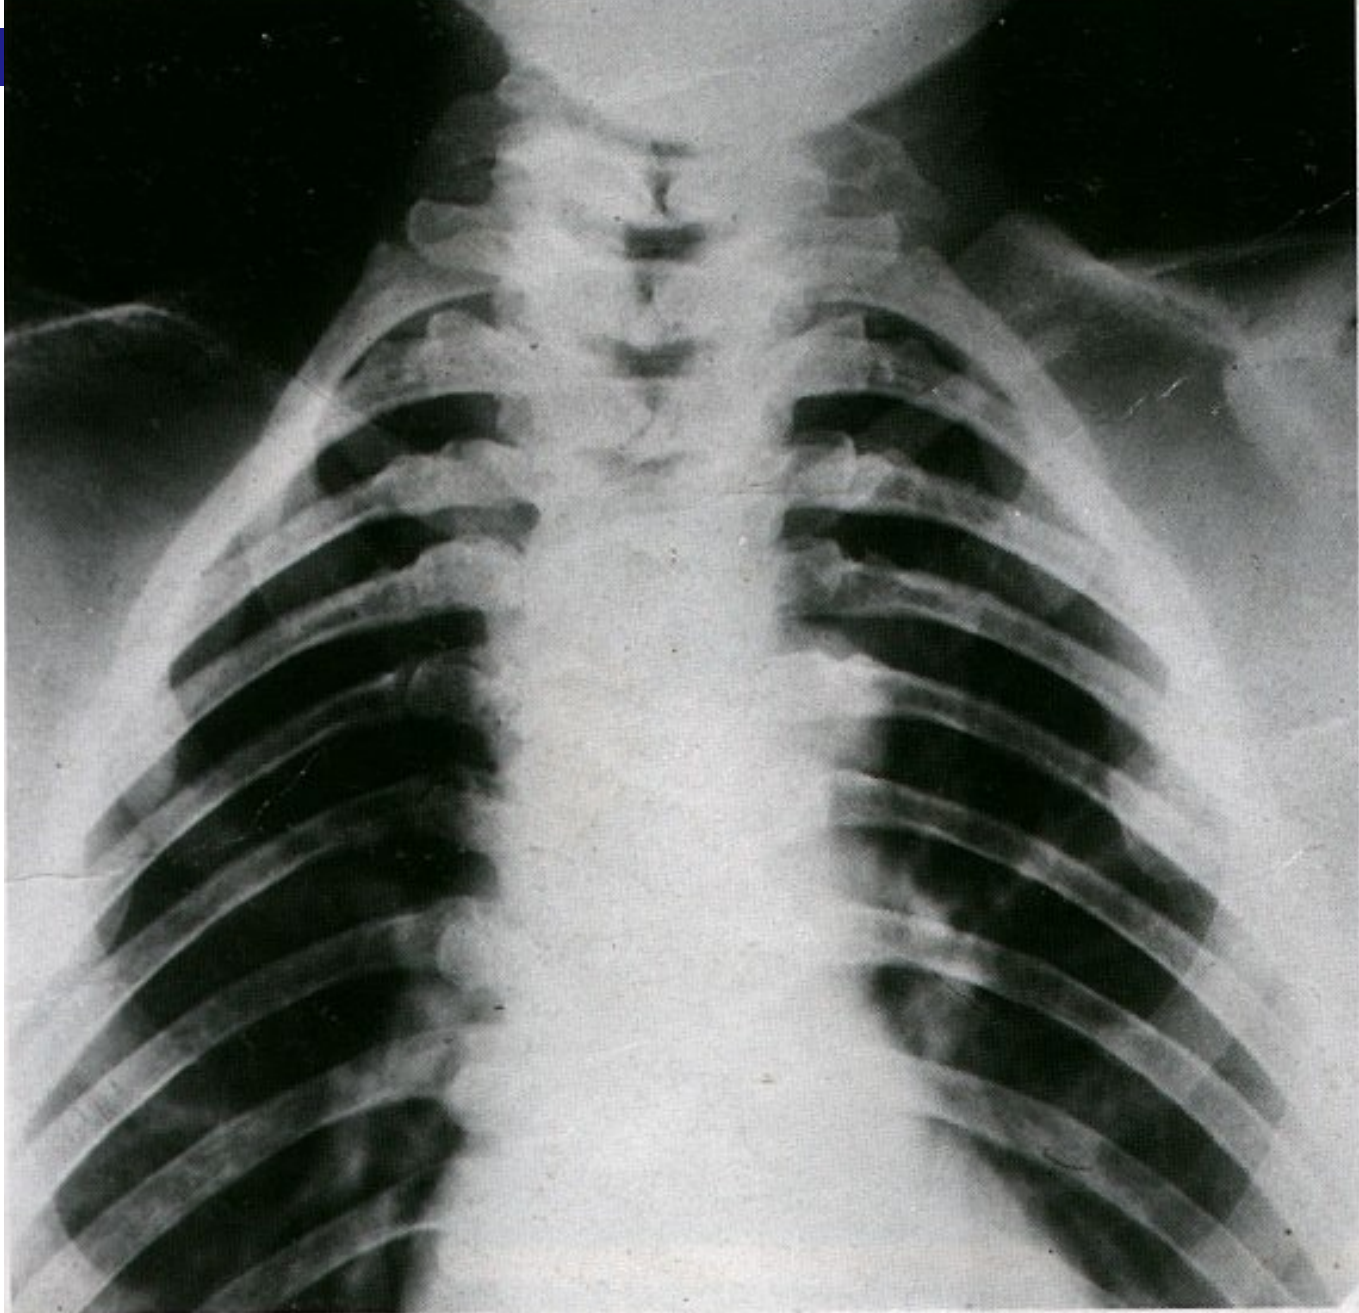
Cleidocranial dysplasia: the radiograph shows absence of clavicles in this disorder.
